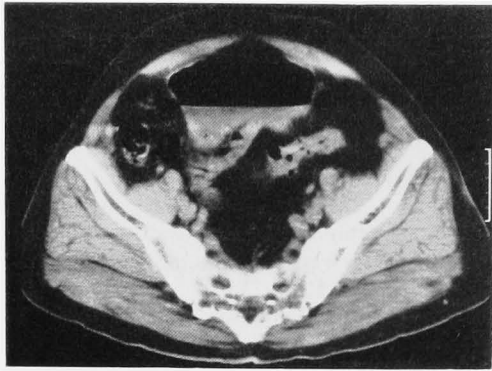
CT scan reveals gas in the lumen of bladder.
